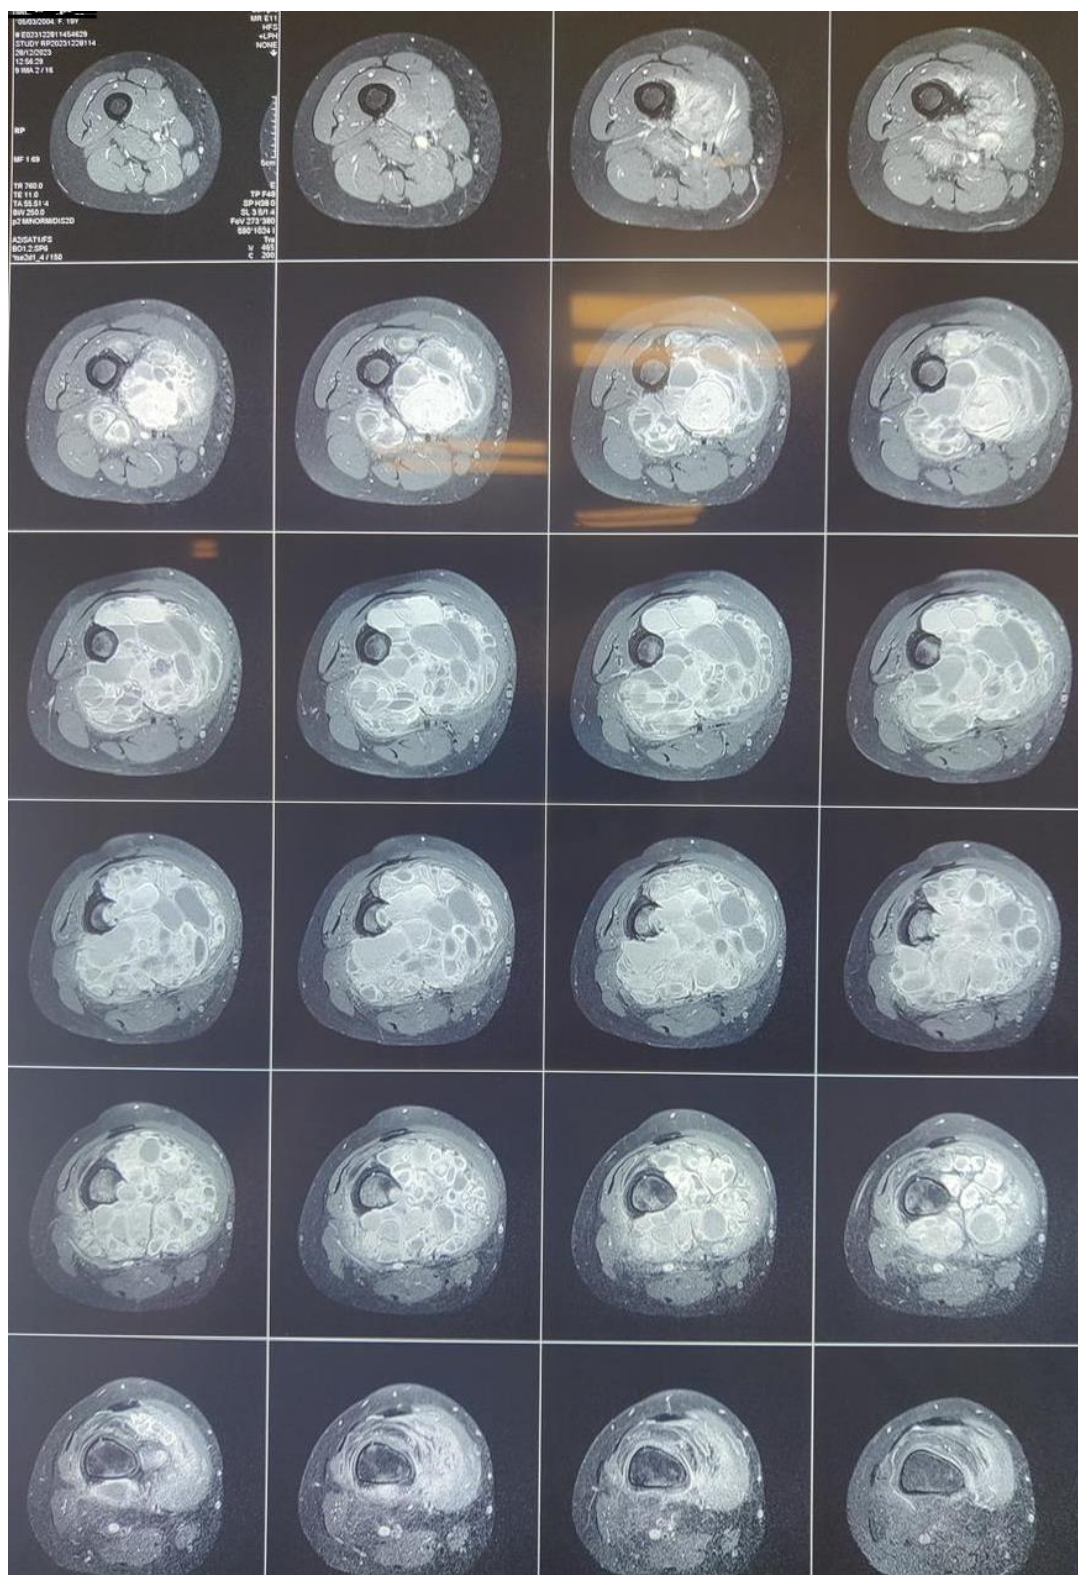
MRI of the right lower limb in T1, FATSAT sequence after gadolinium injection.
